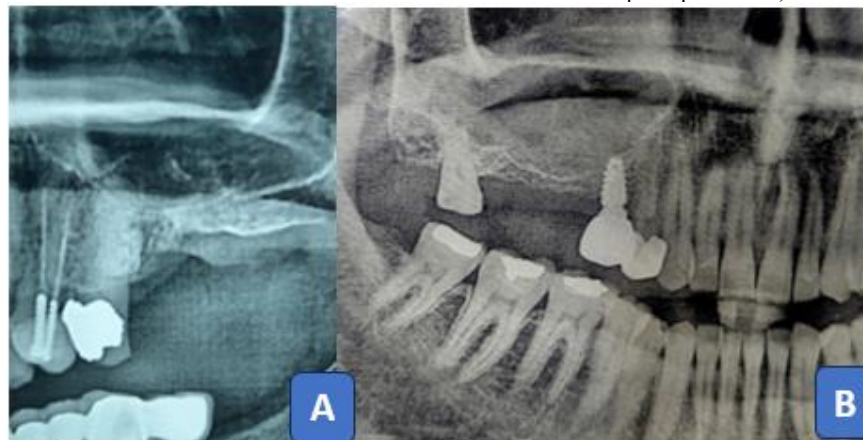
Preoperative orthopantomograms of two patients (A&B) demonstrate insufficient bone height beneath the maxillary sinus due to pneumatization
